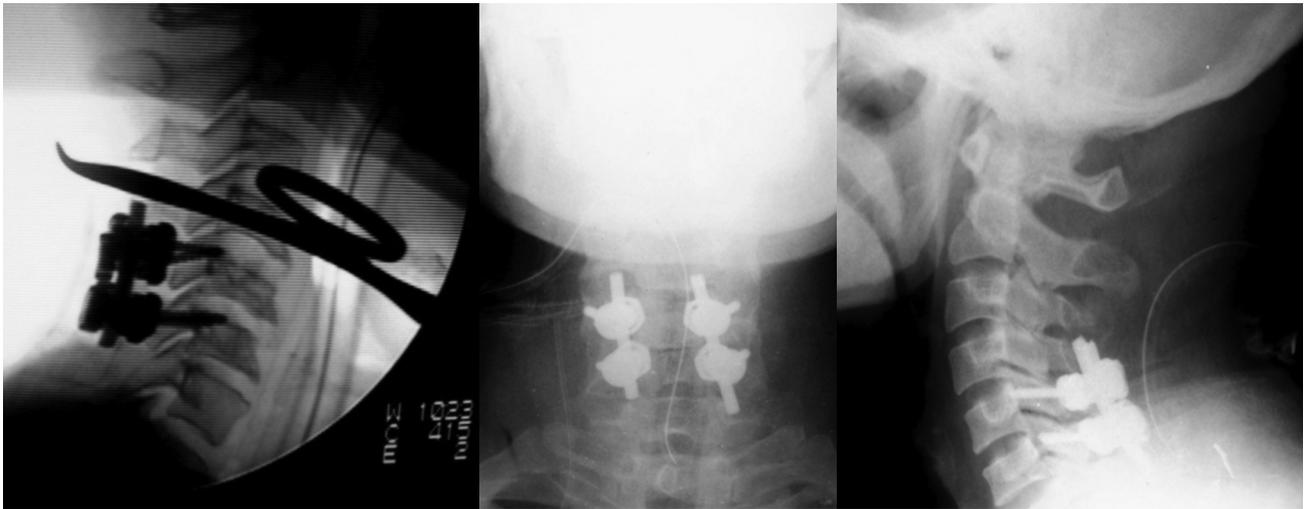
Case of C5-C6 subluxation fixed with Lateral mass screw technique (intraoperative and post-operative radiographs).
